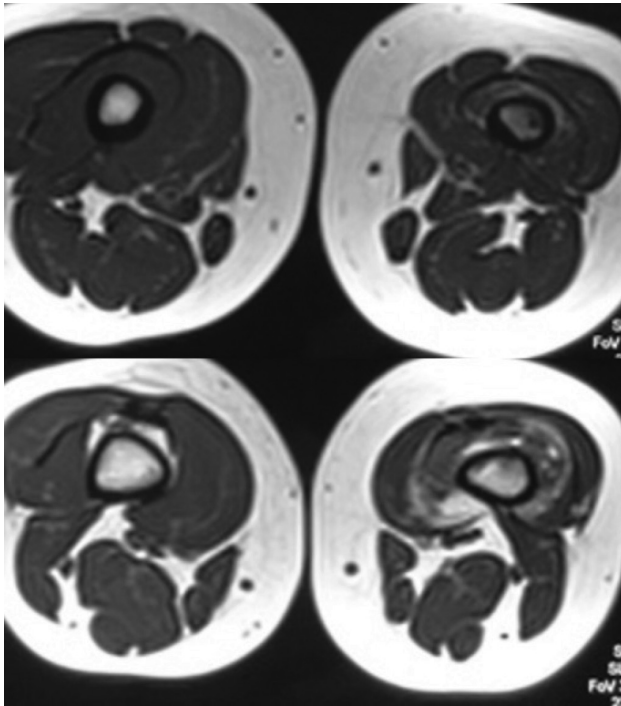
MRI showing a serpiginous soft tissue mass containing signal void areas with extension to knee joint with bone marrow edema and atrophy of vastus intermedius with fatty changes. Axial T1W and T2W (a,b) and sagittal STIR (c) images.
